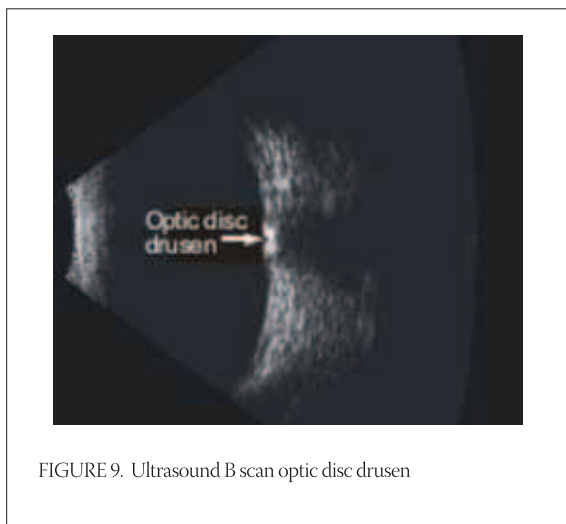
Ultrasound B scan optic disc drusen
